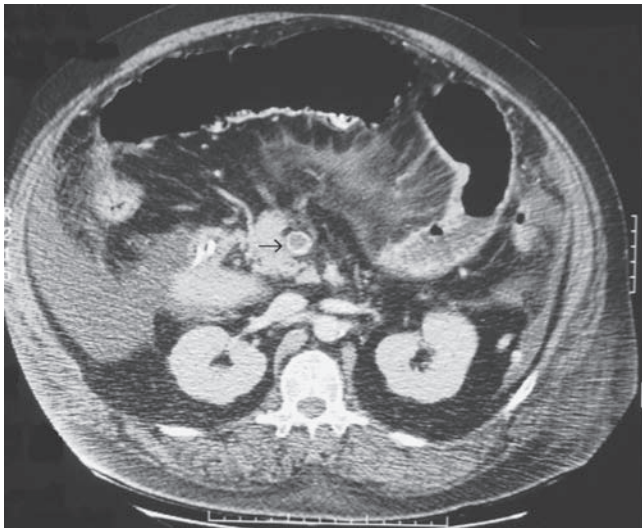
CT scan demonstrating thrombus in the superior mesenteric vein. CT scan is the most accurate diagnostic study in this condition.
